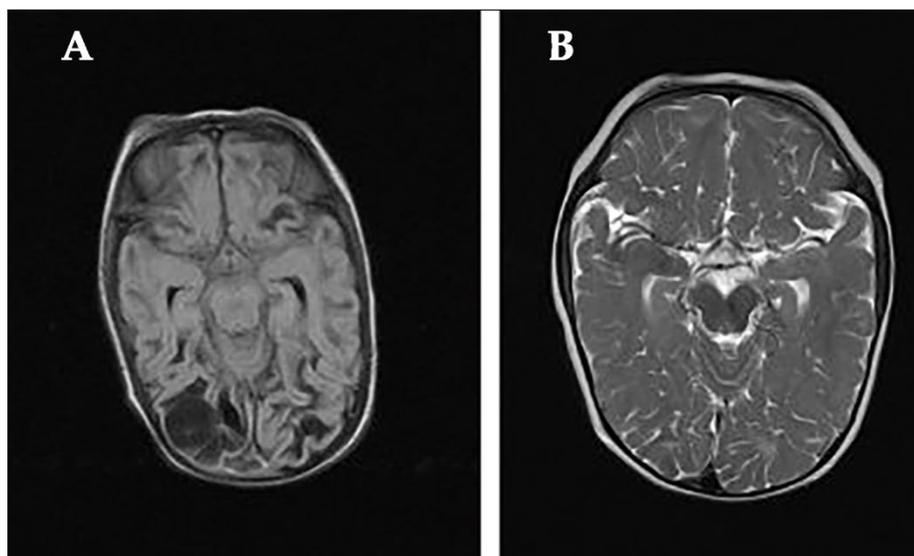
Magnetic Resonance Imaging (MRI) of the brain of a child who suffered a cardiac arrest *in utero*. A) Image taken at 15 days of age. Note the occipital cystic cavities and the marked encephalomalacia. After this image and the prognosis, the parents were asked to authorize the vital disconnection. B) One year later, after being treated with GH and neurorehabilitation beginning on day 16 of age. Although there is a small lack of myelination, cystic cavities disappeared and the brain was recovered. Currently the child is seven years old and lives a normal life.
